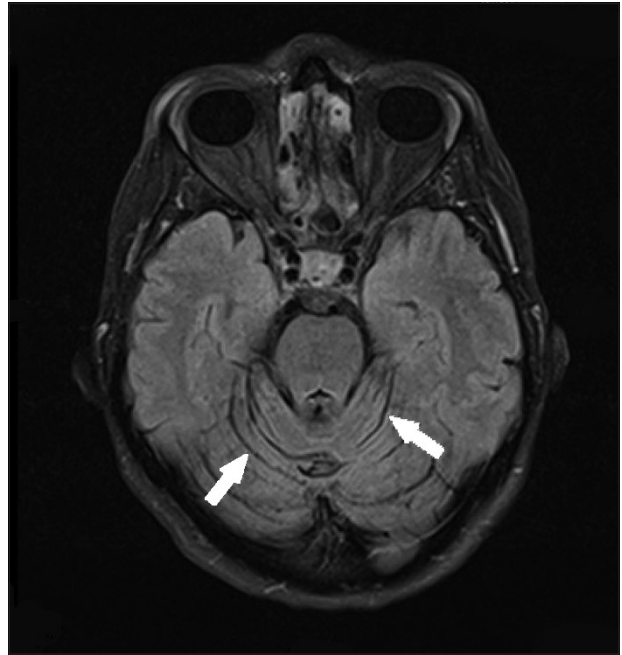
Brain MRI in T2W/Flair mode (axial plane) shows atrophic changes in the cerebellum.
